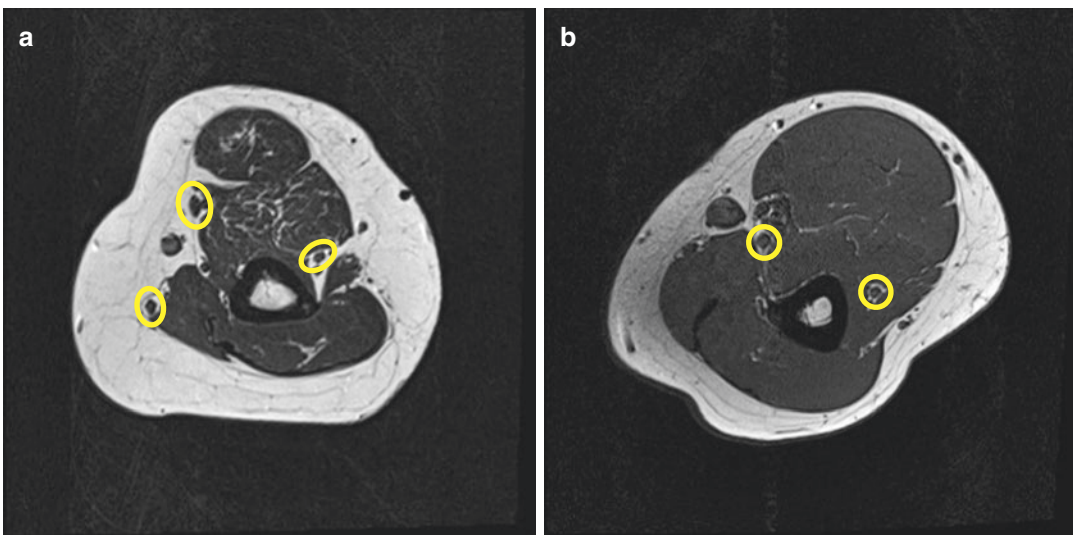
Axial MRI T1 images of the elbow at different levels (a, b) showing the median, ulnar and radial nerves within the round/oval markers
